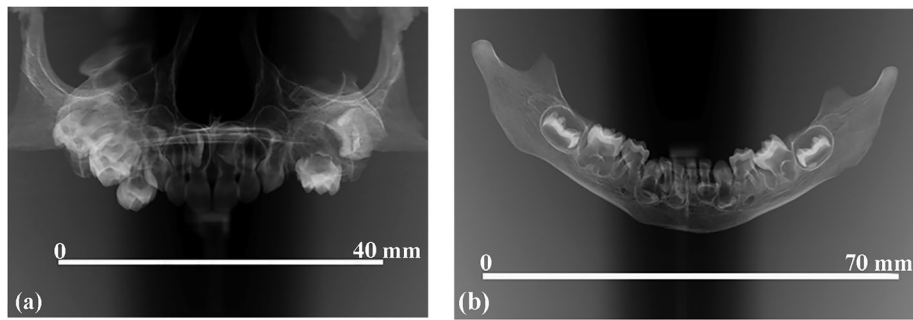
Dental radiographs. SMB 58 – Infant (dental age range $1-1.5 \pm 3$ months, skeletal age range 0–2 years of age). (a) Panoramic radiograph of the maxillary dentition, showing the erupted and semi-erupted primary teeth and the developing permanent teeth within the alveolar. (b) Panoramic radiograph of the mandibular teeth, similarly showing the erupted and semi-erupted deciduous teeth. The developing cusps of the permanent first molars can be clearly seen in the alveolar bone.
